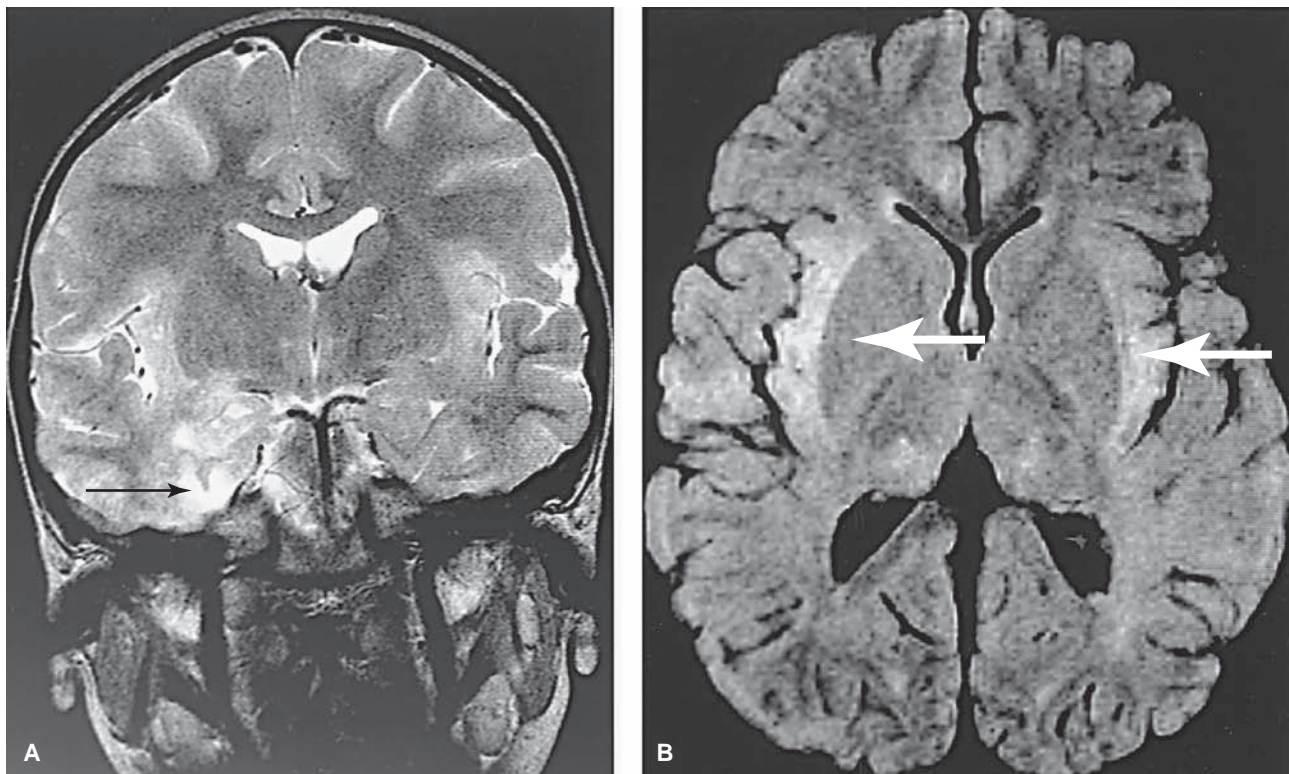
Coronal (A) and axial (B) T₂-weighted magnetic resonance images showing multifocal areas of abnormal signal in the medial aspects of both temporal lobes (*large arrow*) and left posterior parietal lobe (*small arrow*) in a patient with herpes simplex encephalitis.
